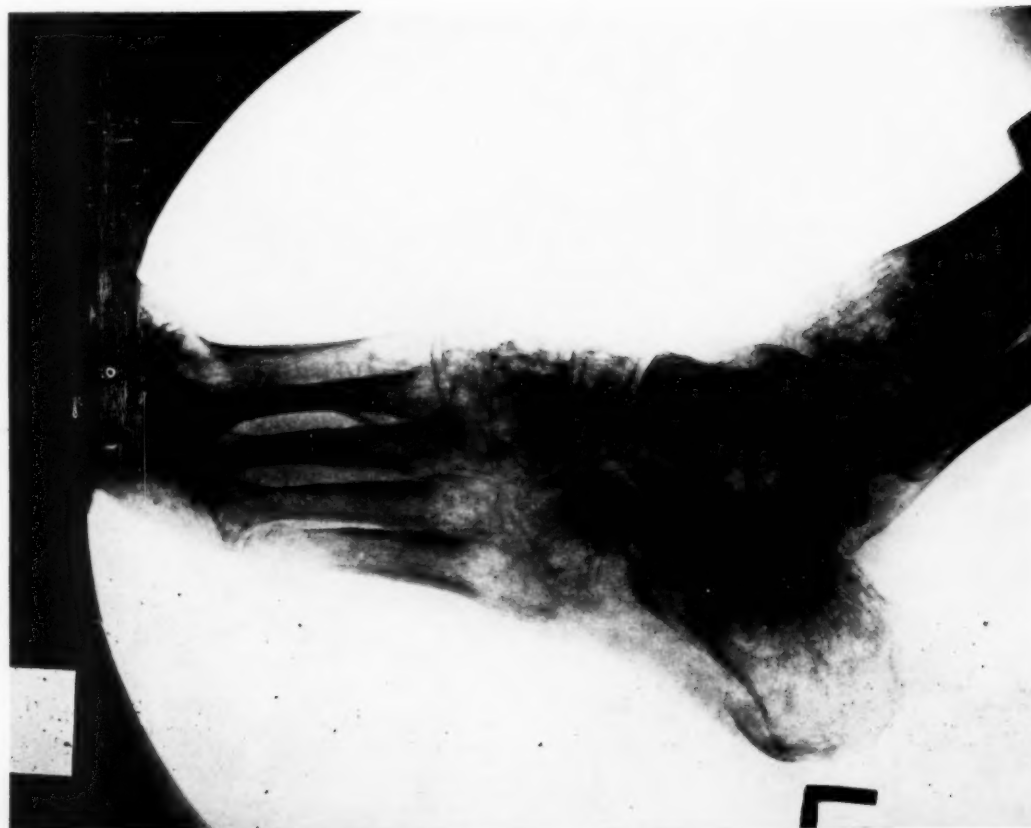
Case 3—Pathol. No. 31024—X-ray, lateral view, of ankle, showing the same changes of osteoporosis present in the knee. (See Figs. 3 and 4.)
